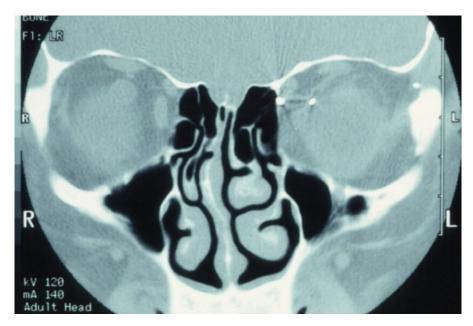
Pictured here is a metallic foreign body in the left orbit. Consider that MRI physics employs a powerful magnet to obtain images. In cases where a metallic foreign body is suspected in the orbit or globe, CT imaging is warranted so as to not violently dislodge the foreign body.
